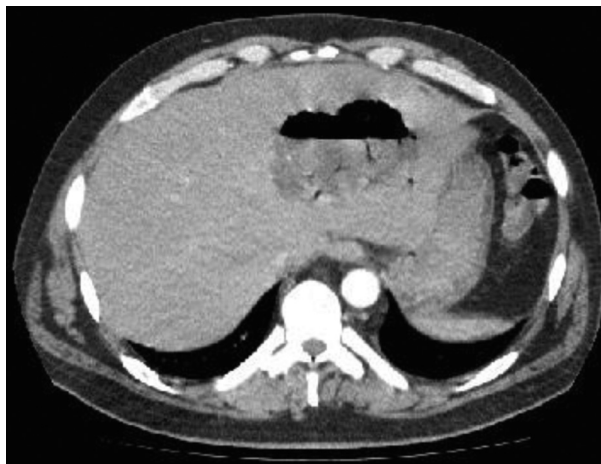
Hepatic abscess in the thorax CT
